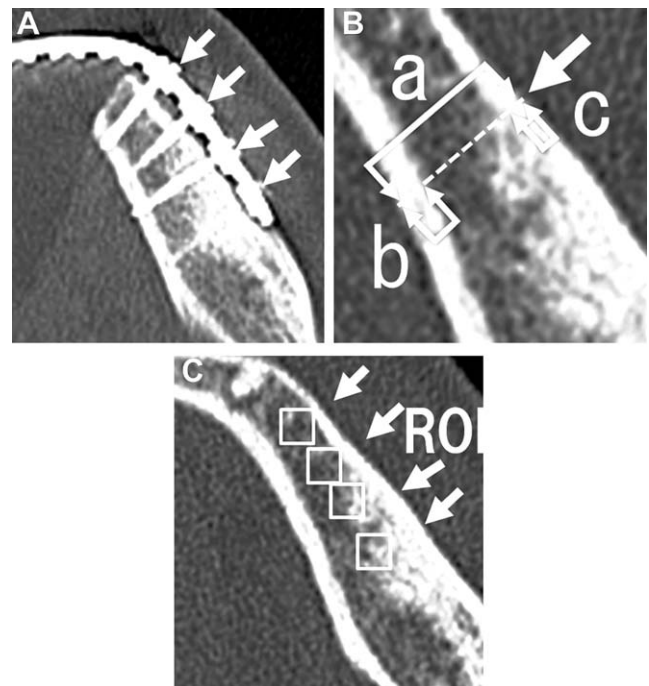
Preoperative computed tomography of fixation screw sites. A, Sites of 4 fixation screws; B, Thickness of the mandible (a), inner table (b), and outer table (c) of cortical bone; C, Hounsfield units measured in a region of interest.
